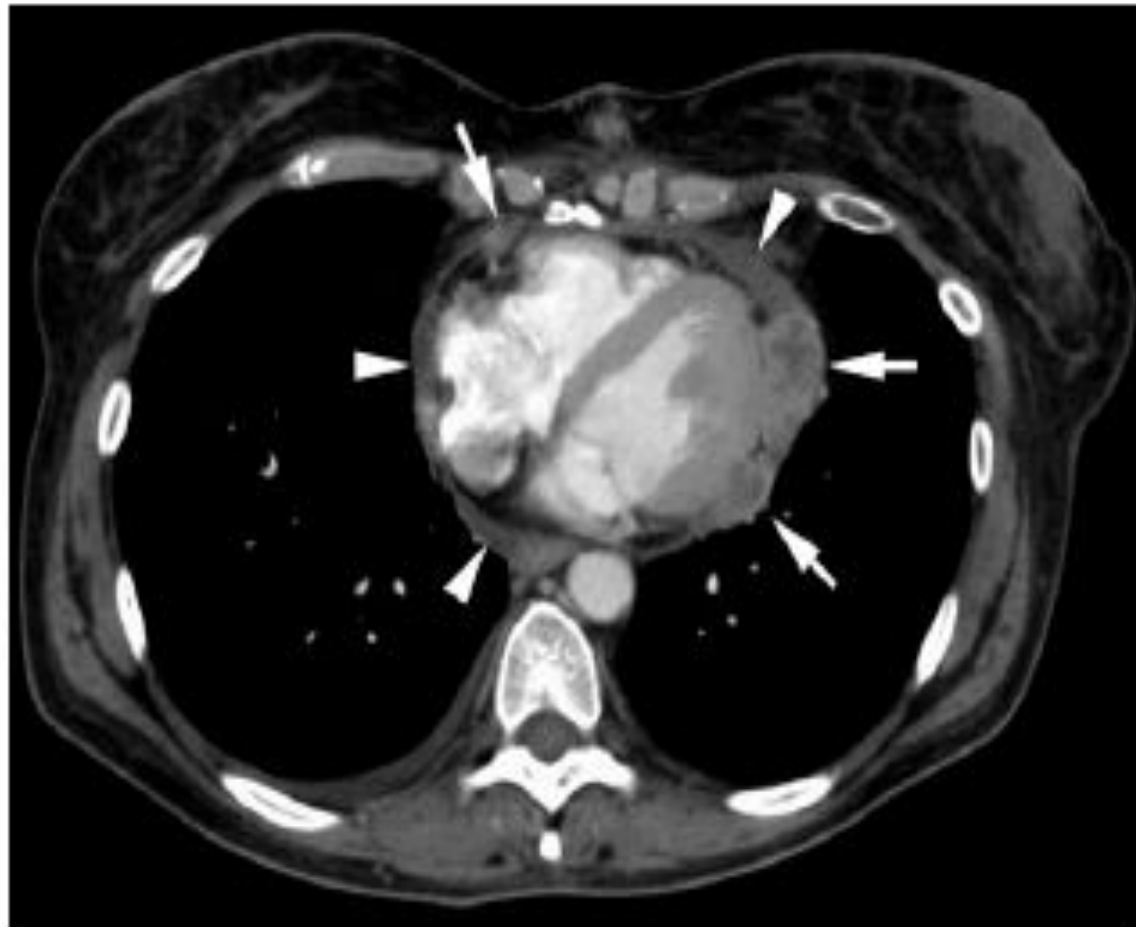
Computed Tomography of the Chest In a Patient With Metastatic Disease
